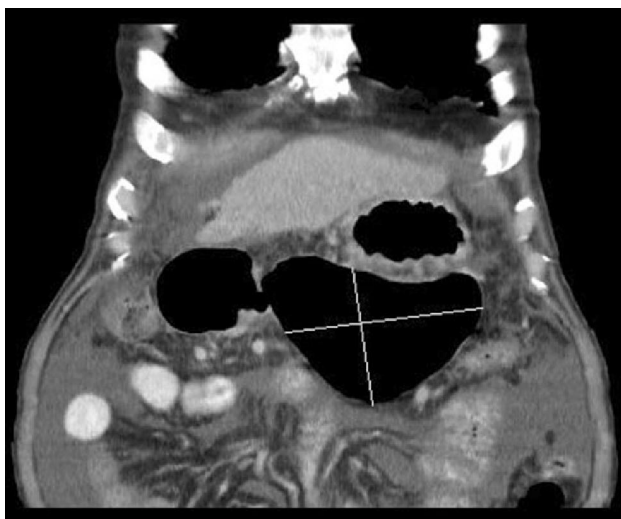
Contrast enhanced CT coronal section showing gastric diverticulum.
